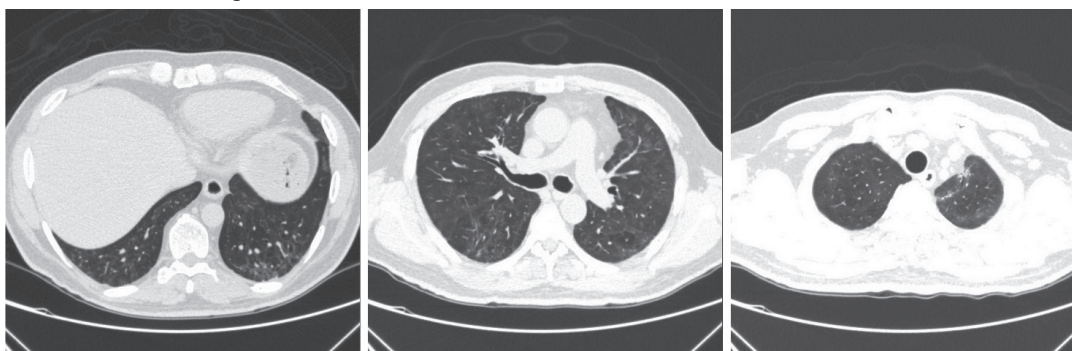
Serial chest CT images at the lower lobe level, at the carina level and at the upper lobe level, which revealed GGO, traction bronchiectasis and interstitial fibrosis in bilateral lungs. CT images showed reductions in the area of GGO and fibrosis compared to the images obtained before treatment.
